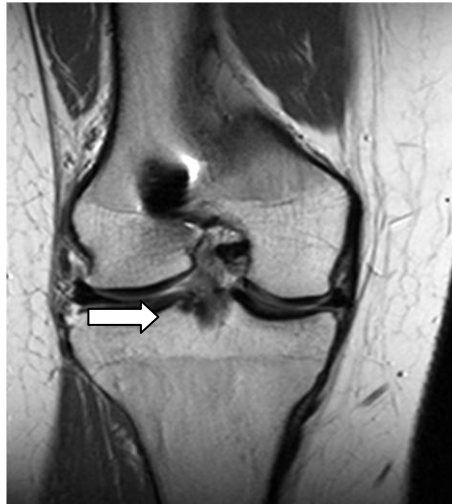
13-year-old girl who presented for routine orthopedic follow-up 3 months after ACL reconstruction using BPTB graft using patellar tendon allograft. Coronal MR image shows continuity of graft fibers. There is high-signal-intensity edema in graft. This is a normal finding during remodeling phase, which occurs between 4 and 8 months after surgery *Quoted from (Casagrande 2014)*.
